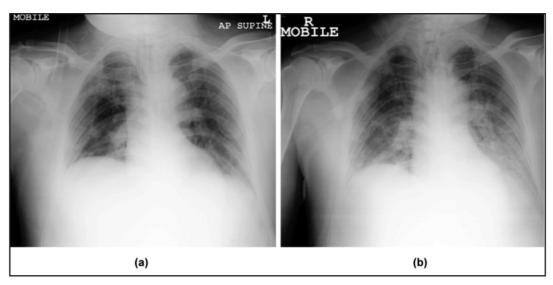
(a) Chest X-ray (CXR) POD1, (b) CXR POD4.
